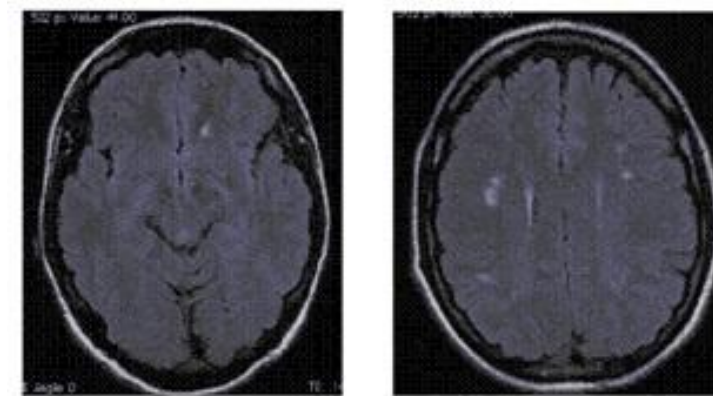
Axial T2-weighted FLAIR images showing (left) a left frontal periventricular lesion and (right) multiple lesions; the right parietal lesion involves juxtacortical U fibres
